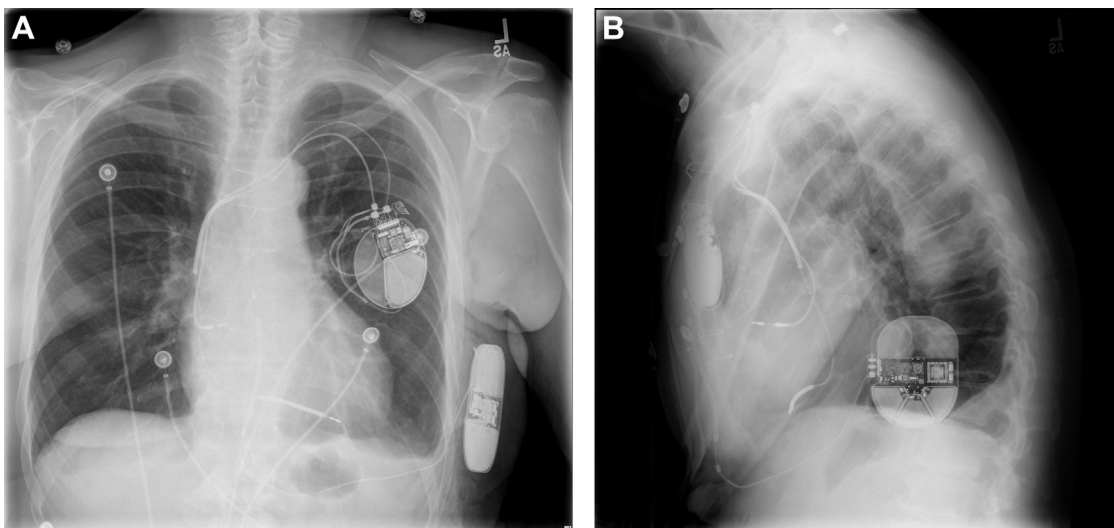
Anterior-posterior (A) and lateral (B) view chest radiographs following subcutaneous implantable cardioverter-defibrillator implantation.
